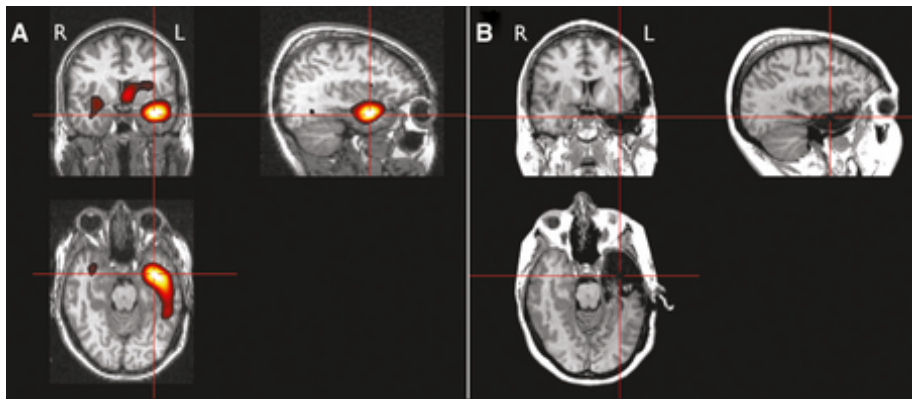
SISCOM analysis and MRI coregistration. *A* shows SISCOM analysis performed on preoperative MRI. *B* shows the coregistered postoperative MRI, which presents a resection consistent with SISCOM localization [1].
